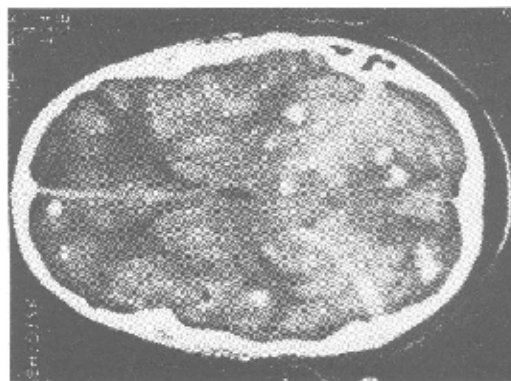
Brain CT scan of the patient revealing globular nodules in supra and infra tentorial area
